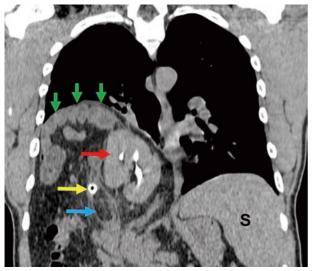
Coronal cut of CT scan of a 32-year-old diagnosed as appendicitis, shows elevation of the right diaphragmatic dome (green arrows), right kidney drown upward below the diaphragm, backwards and above the liver (red arrow), appendicolith (yellow arrow) and periappendicial infiltrate in retroperitoneal space (blue arrow). S: Spleen.
